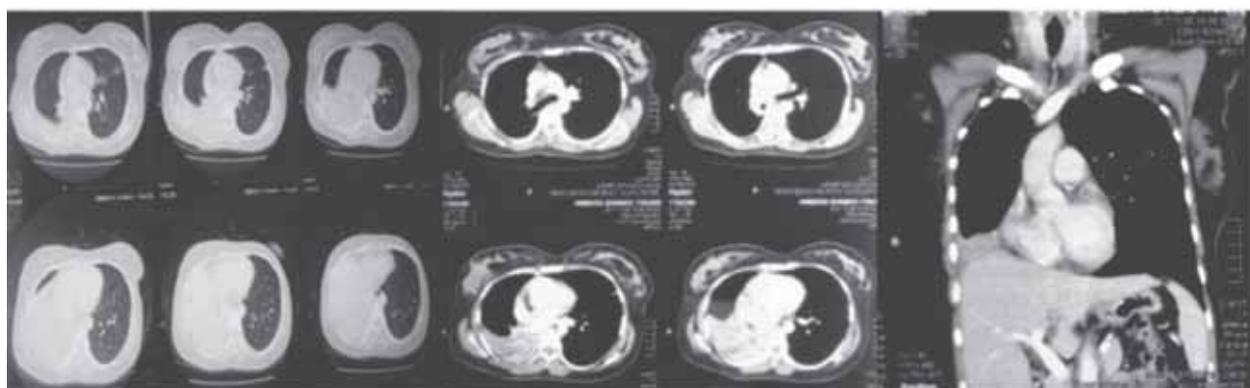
CT chest with contrast, pulmonary window (left), mediastinal window axial images (middle) and coronal image (right) showing loss of lung volume on right side, narrowing of right main bronchus and collapse of right middle and lower lobes.
